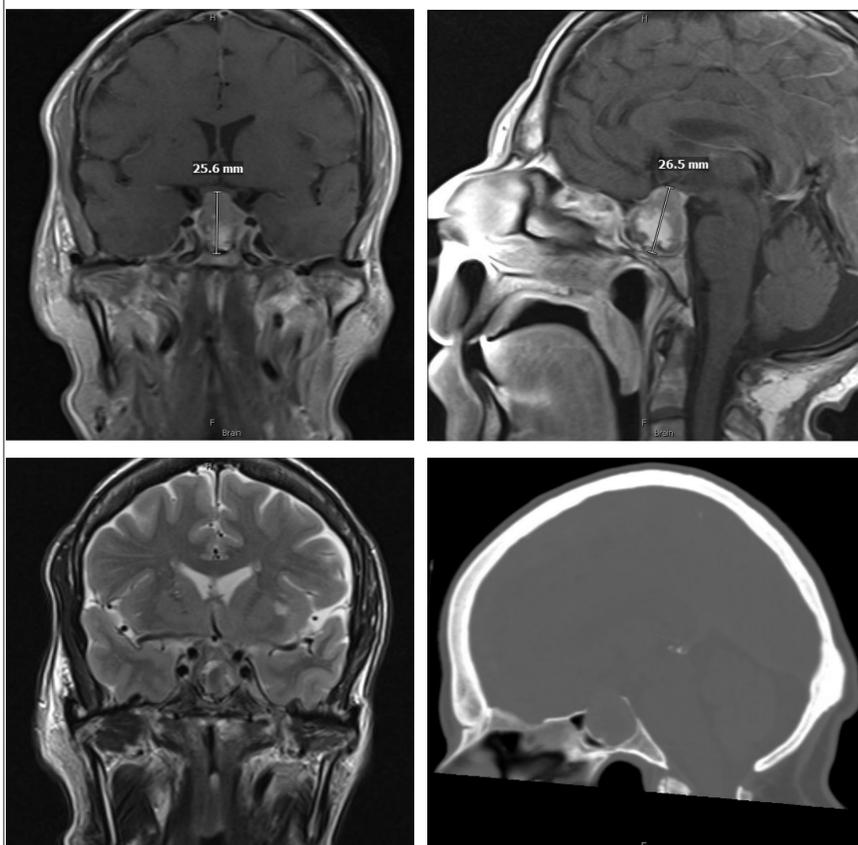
Pre-operative imaging. MRI T1 post contrast in coronal and sagittal planes, coronal T2 MRI and sagittal CT bone.
